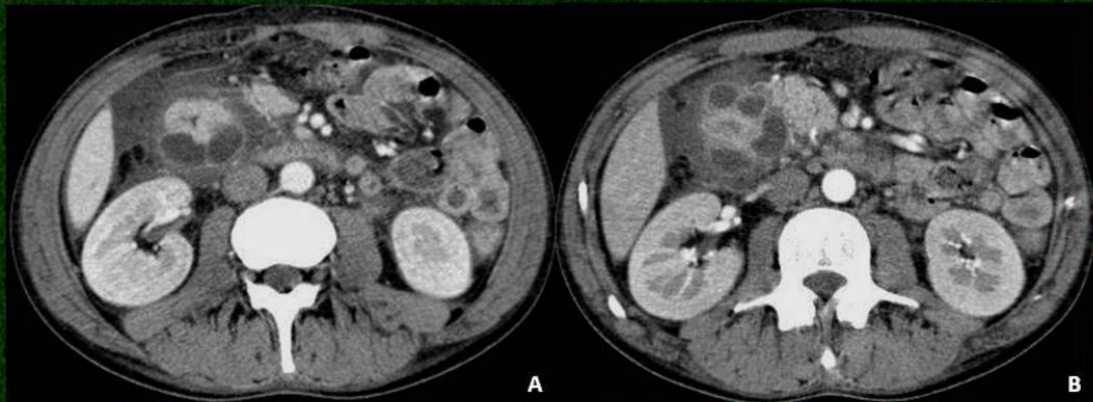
Cystic dystrophy of the duodenal wall in a woman with abdominal pain. Abdominal contrast-enhanced CT scan discloses multiple cysts around and in the thickness of the duodenal wall. Densification of the peri-duodenal fat and a small amount of ascitis are also seen.
